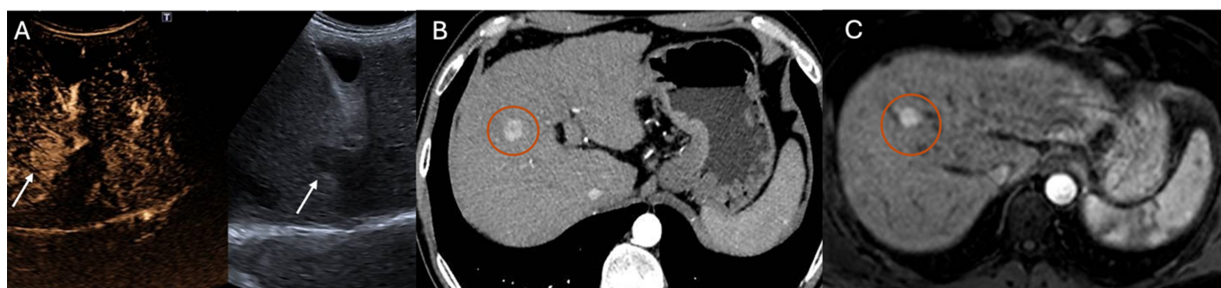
Detection of HCC using CEUS after contrast agent administration (SonoVue®) (A), arterial-phase CT (B), and arterial-phase MRI (C). Arrows in (A) indicate the HCC lesion, while circles in (B and C) highlight the tumor area identified on cross-sectional imaging. HCC: Hepatocellular carcinoma; CEUS: contrast-enhanced ultrasound; CT: computed tomography; MRI: magnetic resonance imaging.
